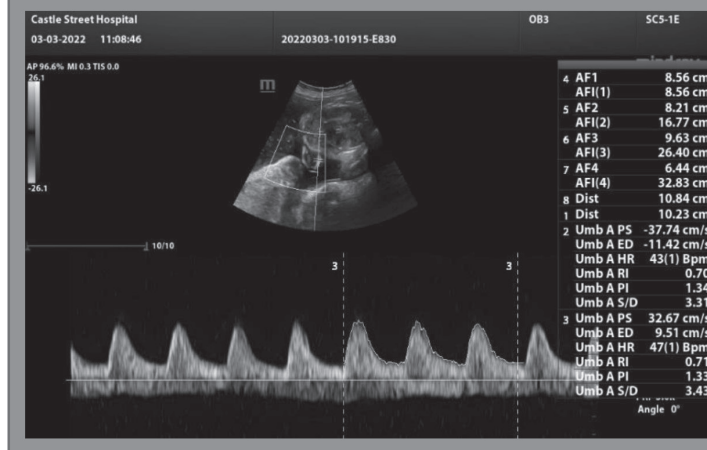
Umbilical artery Doppler of pump twin shows normal flow pattern.
